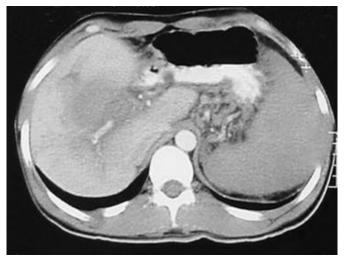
The large hypodense mass on abdomino-pelvic spiral CT-scanning with triphasic contrast media
